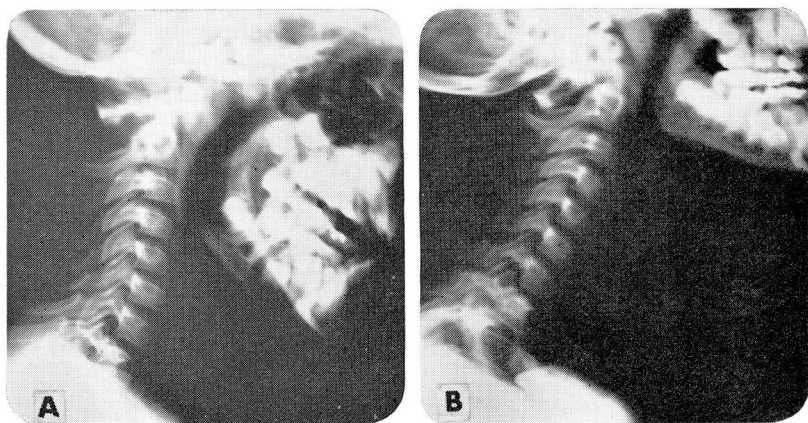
Roentgenograms of lateral cervical spine. A, shows forward displacement of the first cervical vertebra in flexion. B, shows posterior displacement of the first cervical vertebra in extension.
